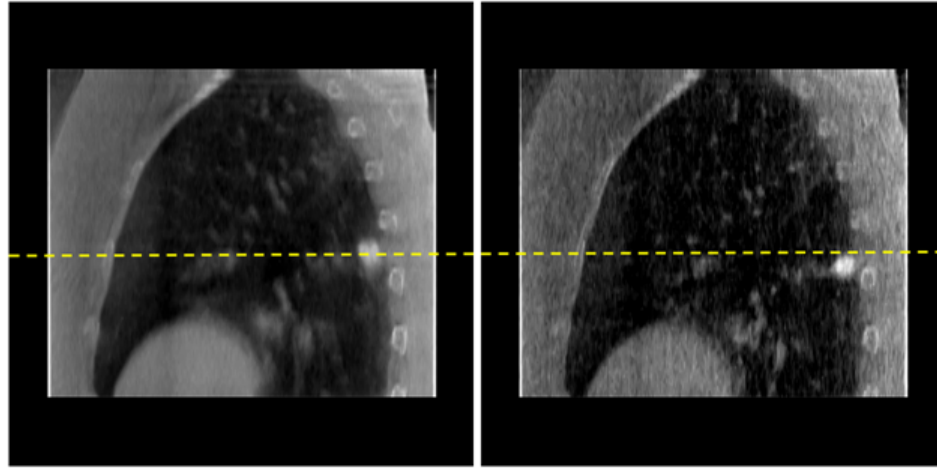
Comparison of average CBCT and 4D-CBCT. Left: average CBCT; Right: 4D-CBCT image at end-inhale. Both images were reconstructed from the same raw data.
